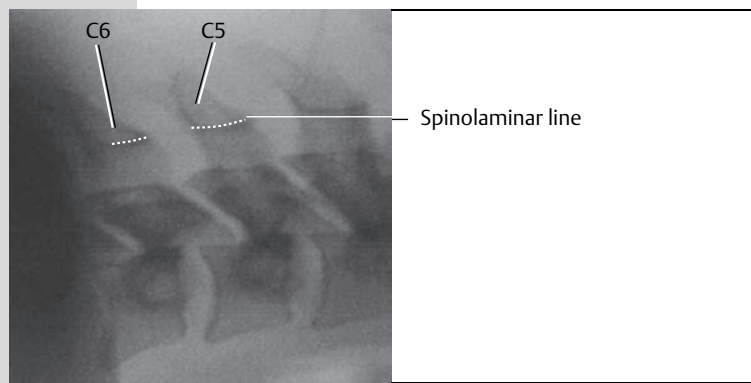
Locating the height of the cannula between C5 and C6 using a lateral radiograph.
